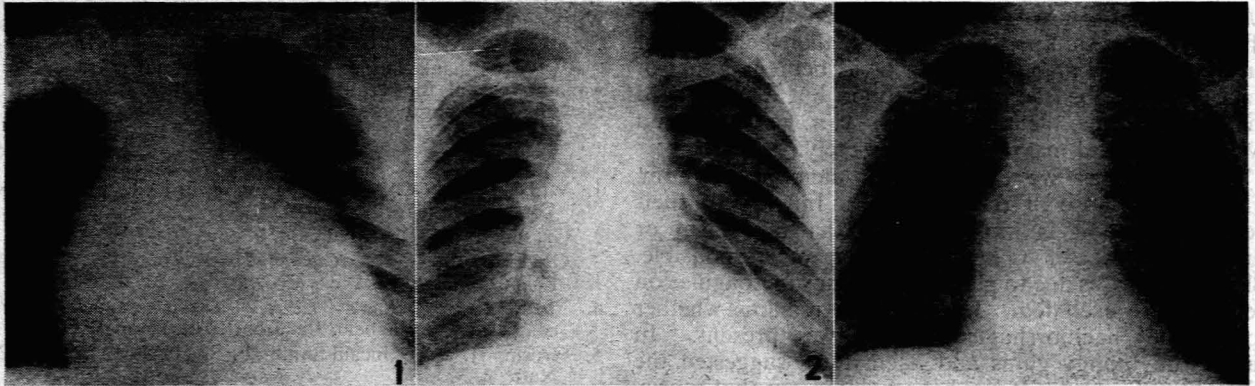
Case 1. Bedside X-ray, showing enlargement of the heart.
